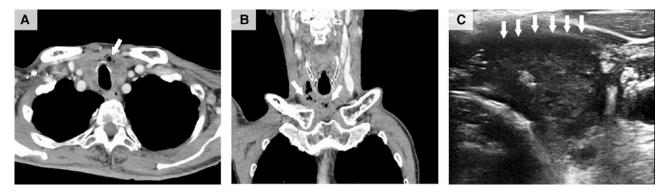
Thyroidal air spaces observed on cervical contrast-enhanced computed tomography and thyroid ultrasonography.
